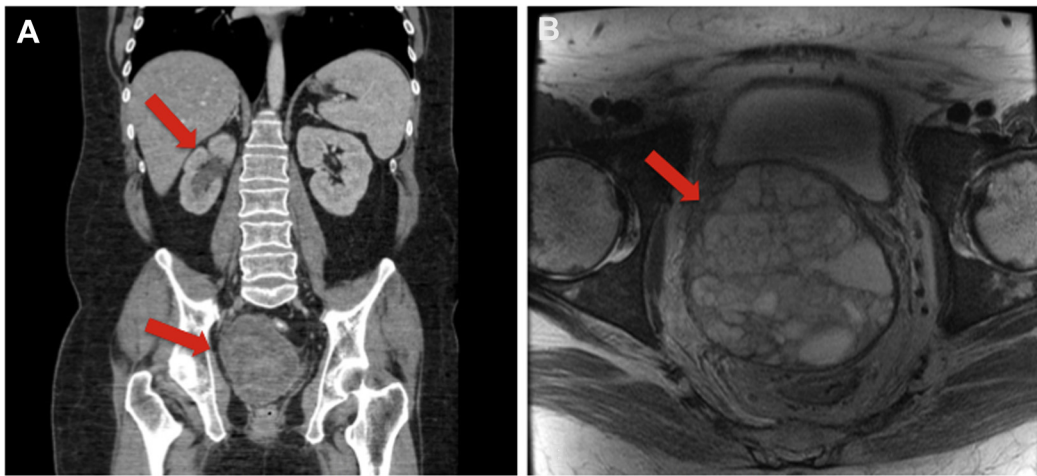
CT (A) and MRI (B) after BEP \times 4 cycles, demonstrating growing teratoma the red arrows point to the "growing teratoma".
